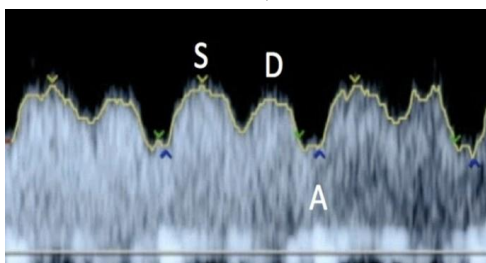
Normal ductus venosus Doppler waveform. S: peak systolic velocity during ventricular systole; D: passive ventricular filling during the first half of diastole; A(A-wave): atrial contraction during the second half of diastole or "atrial kick". Melber,⁹
